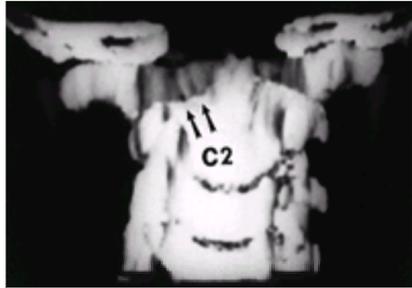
A three-dimensional computed tomography scan of the upper cervical spine in a child with familial cervical dysplasia. The left superior facet of C2 is shallow and hypoplastic (arrows). (From ref. 52, with permission.)
